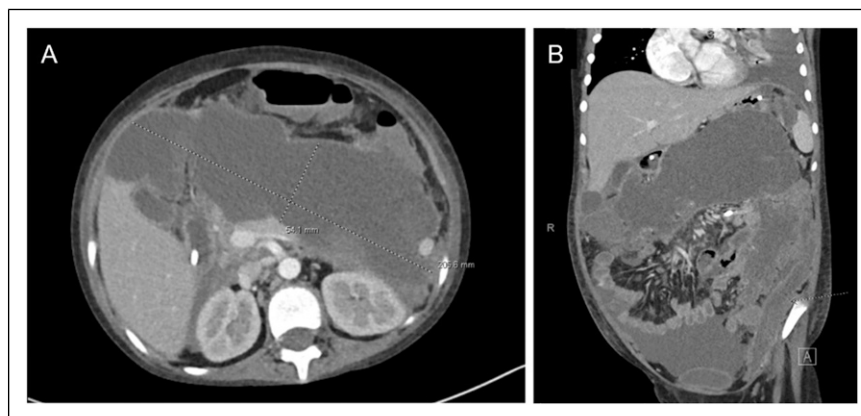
CT abdomen and pelvis. (A) Axial and (B) coronal views demonstrating large pancreatic pseudocyst ($20.6 \times 5.4 \times 8.4$ cm).
